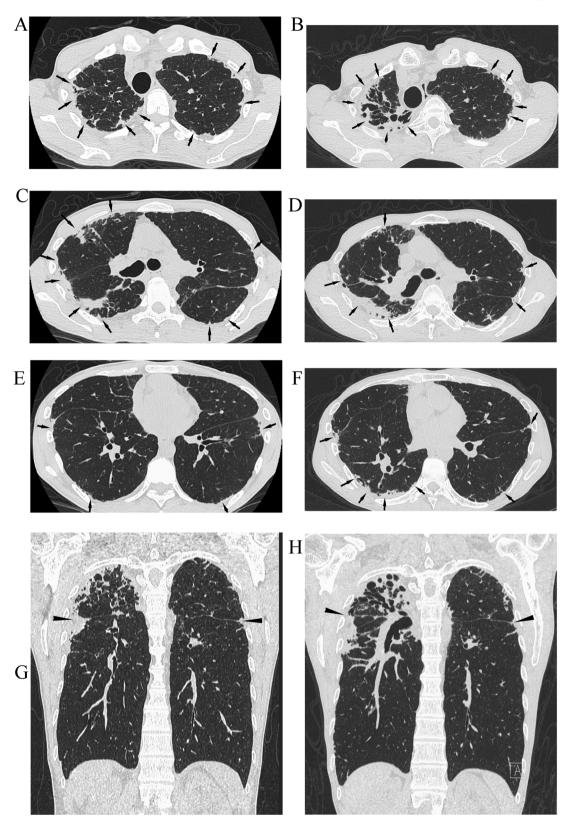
37-year-old man with pleuroparenchymal fibroelastosis (PPFE)-like finding on CTs detected for an investigation of pleuritis. Initial CT images at the apical, bifurcation and lower levels show bilateral and subpleural dense consolidation (arrows) with traction bronchiectasis and distortion consistent with PPFE (3A, C, E, G). CT images taken15-years later (3B, D, F, H) show increased consolidation with associated severe volume loss and distortion. The upward shift of the interlobar fissures (arrowheads) and the shrinkage of thoracic cage are also recognized.
